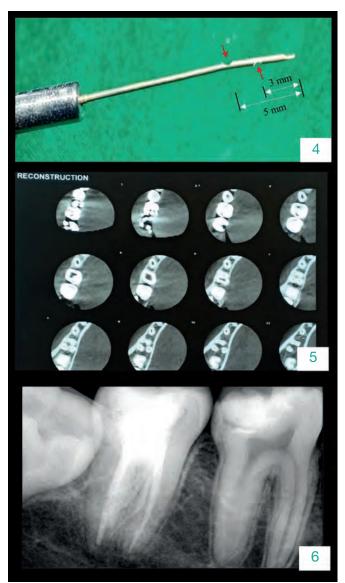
Cartridge modification. Figure 5. Postoperative CBCT. Figure 6. 1-year follow-up intraoral radiograph.
